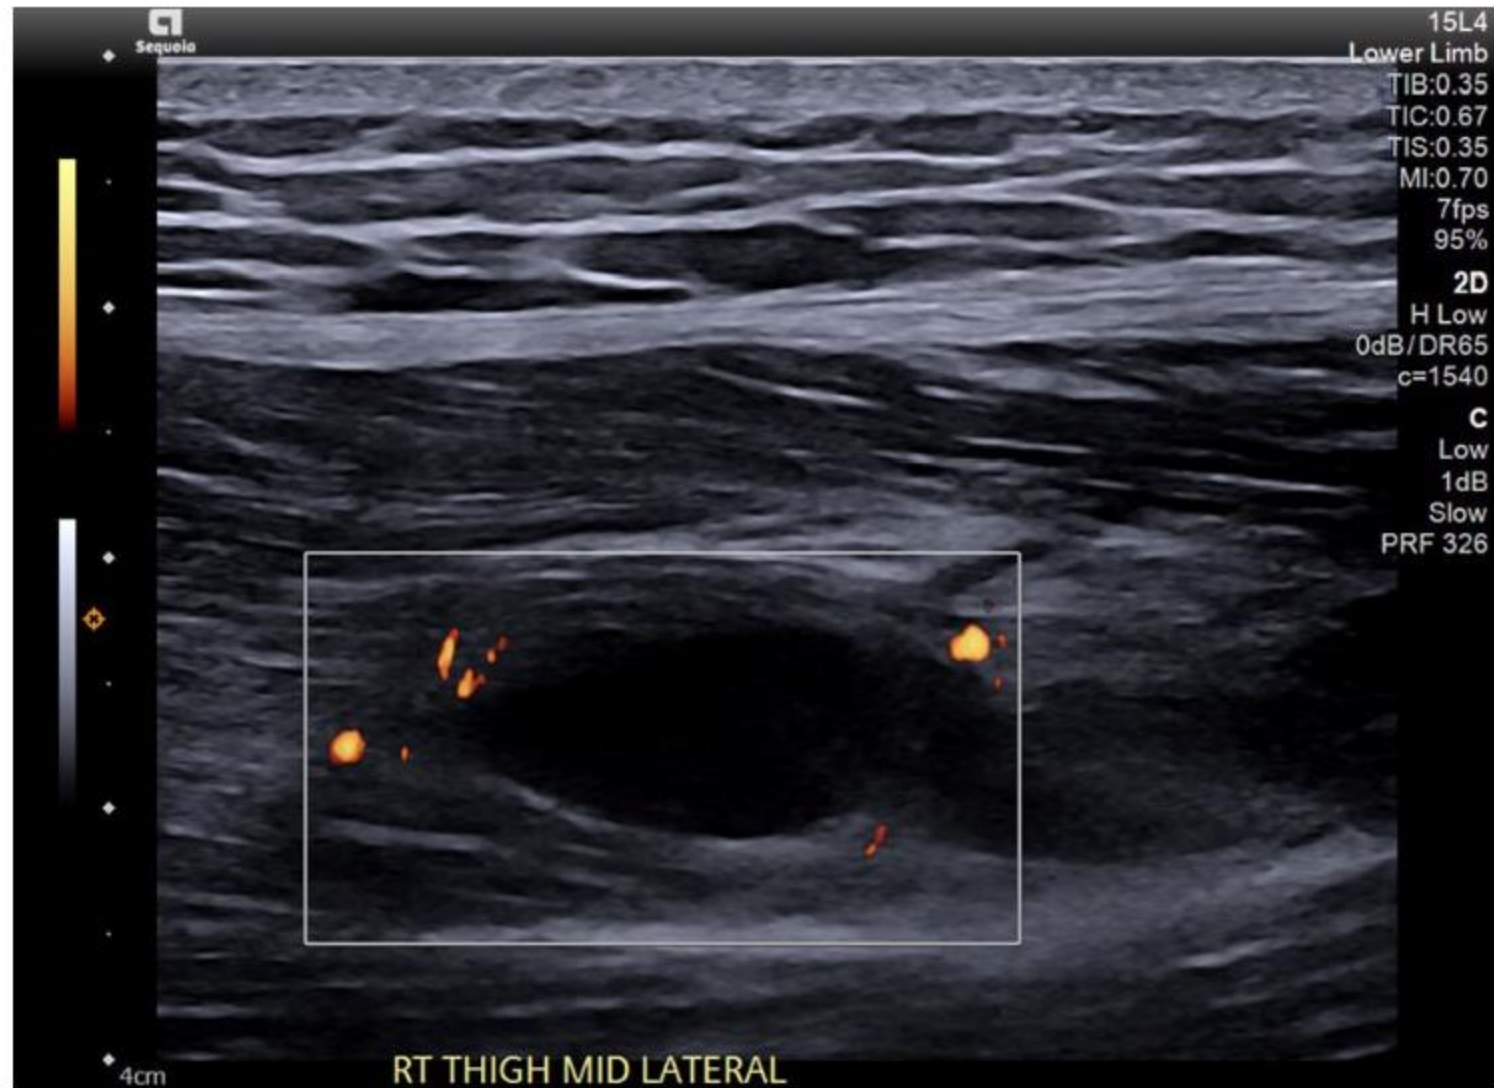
Transverse ultrasound image of an intramuscular haematoma in the right lateral thigh from the same patient as [Figure 7](#). Microvascular imaging reveals no vascularity in the haematoma.
